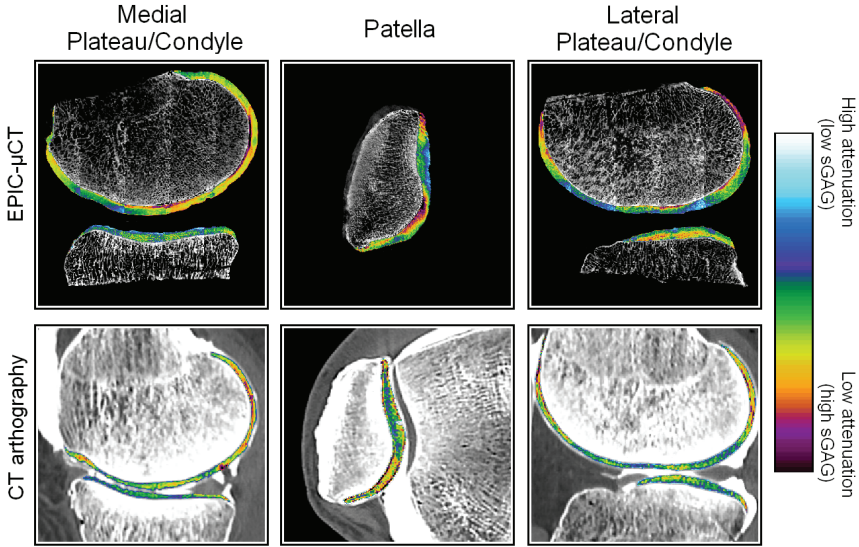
Images of both EPIC- μ CT and CT arthrography. The attenuation of cartilage regions is visualized in colour and representative for sGAG content. High levels of attenuation represent a low sGAG-distribution.
